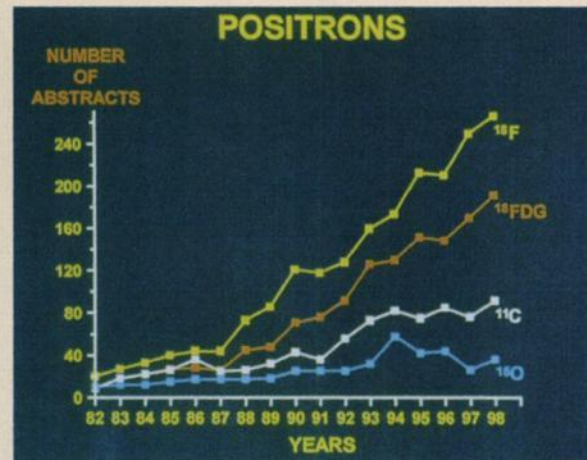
Continuing high rate of increase in ¹⁸F and ¹⁸F-FDG presentations at SNM Annual Meeting.
